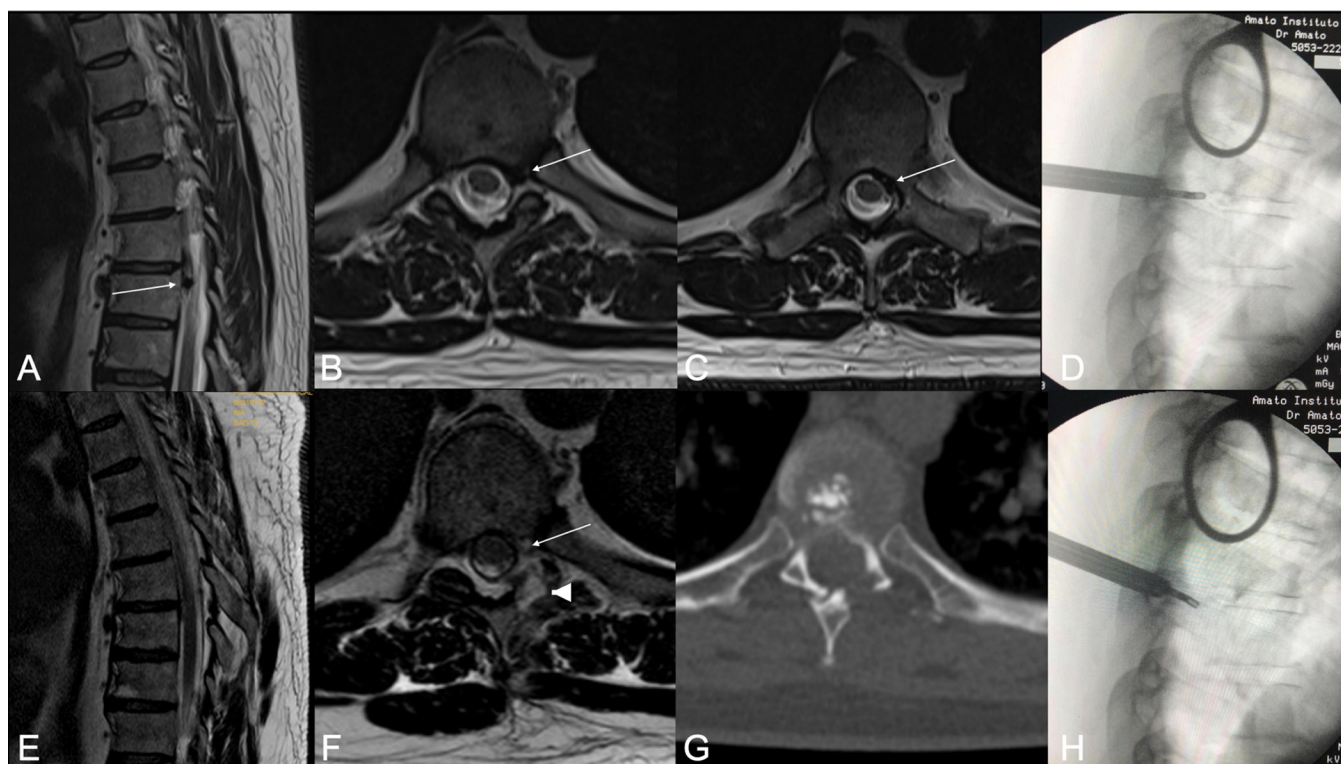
(A) Sagittal T2-weighted magnetic resonance imaging (MRI) showing the extruded disc herniation with caudal migration (arrow). (B and C) Axial T2-weighted MRI showing the paramedian disc herniation with migration medial to pedicle. (E and F) Postoperative images showing good resection of the disc herniation. It is possible to see the partial facetectomy (arrow head), with complete preservation of the spinal muscles. (G) Computed tomographic image showing partial facetectomy. (D and H) Intraoperative images showing access to the intervertebral disc and manipulation of the instrument medial to the pedicle.
